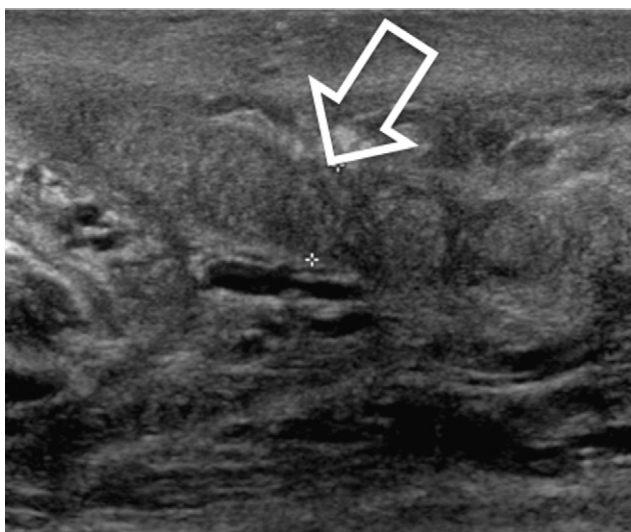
Epididymitis. B-mode sonography: thickening of the body of the epididymis (arrow).
